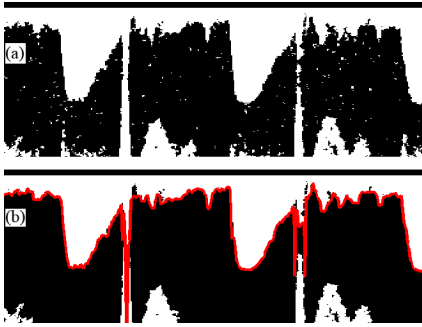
An example binary Doppler image: (a) noisy/spurious image, (b) same image after noise removal together with superimposed automatically detected initial velocity profile.
